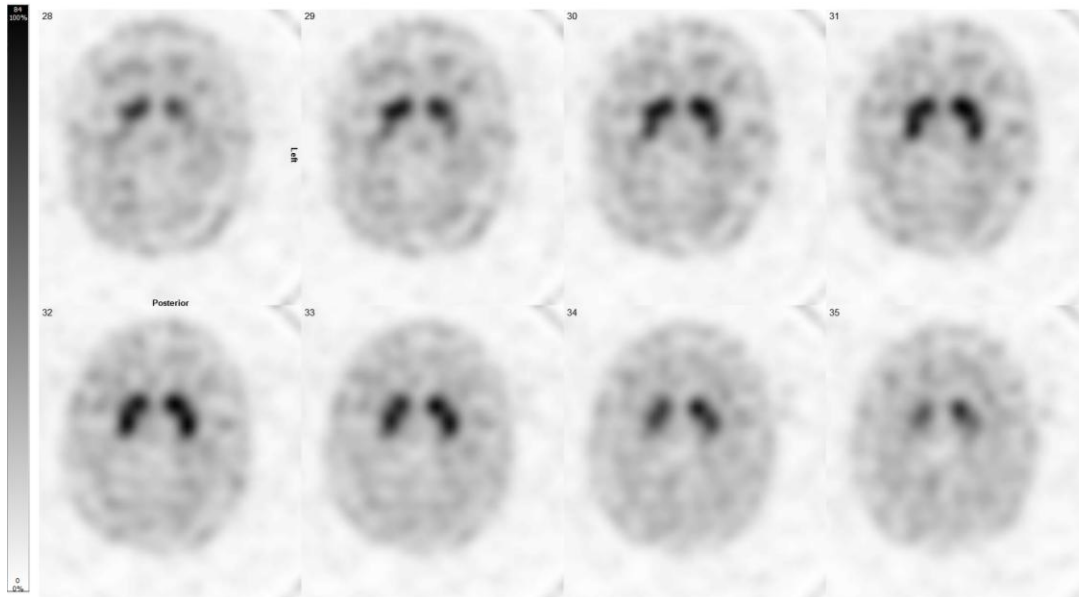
A series of transverse slices from a normal ^{123}I -FP-B-CIT SPECT scan
